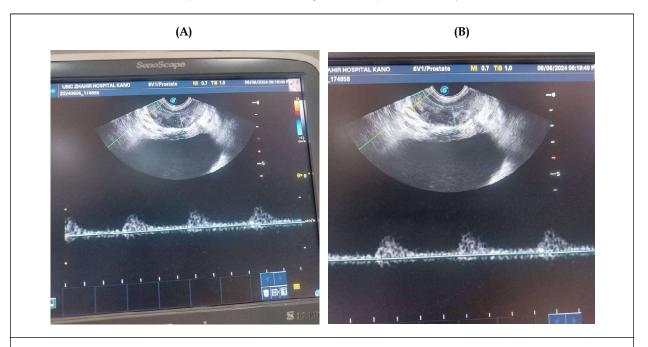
Doppler velocimetry of the prostate capsular arteries demonstrating low-resistive monophasic waveforms. Both A and B demonstrates unidirectional (monophasic) waveform that did not cross the zero-flow baseline throughout the cardiac cycle
